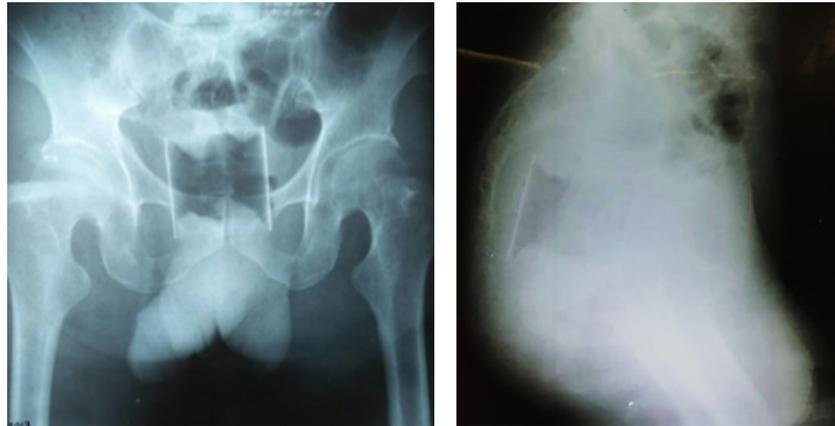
Plain X-ray of tubular foreign bodies in rectosigmoid region
